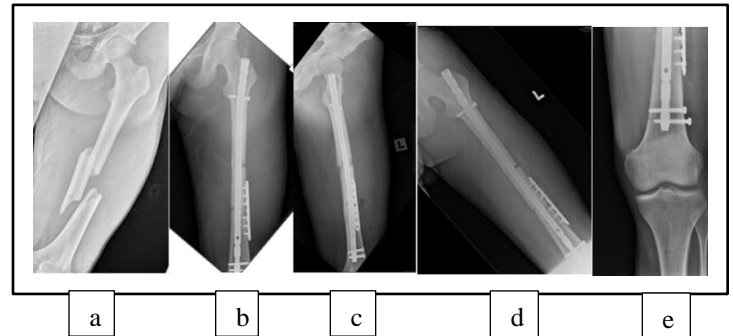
X-rays (a) Pre-operative, (b, c) operation day, 3 weeks post-operative
